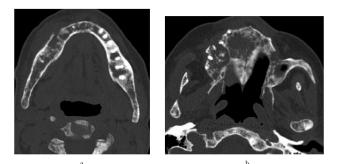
(case 16). A 53-year-old female patient with multiple metastases in the maxilla and mandible. (a and b) Axial mandible computed tomography showing multiple lytic destructive lesions (metastases) in the mandible and the maxilla.
